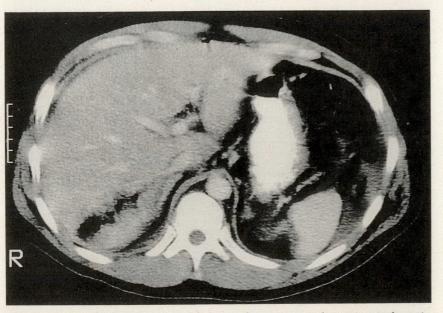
Case 2. Computed tomography scan demonstrating laceration in hepatic segments 6 and 7, with gas.
